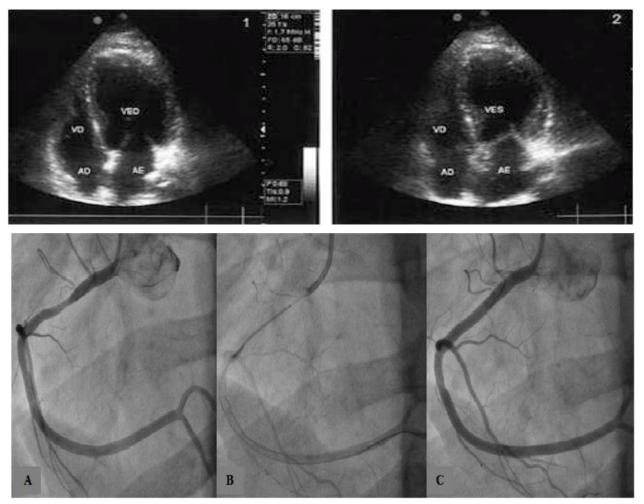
Echocardiogram at admission: Hypokinesia of inferior wall with global left ventricular function preserved.
